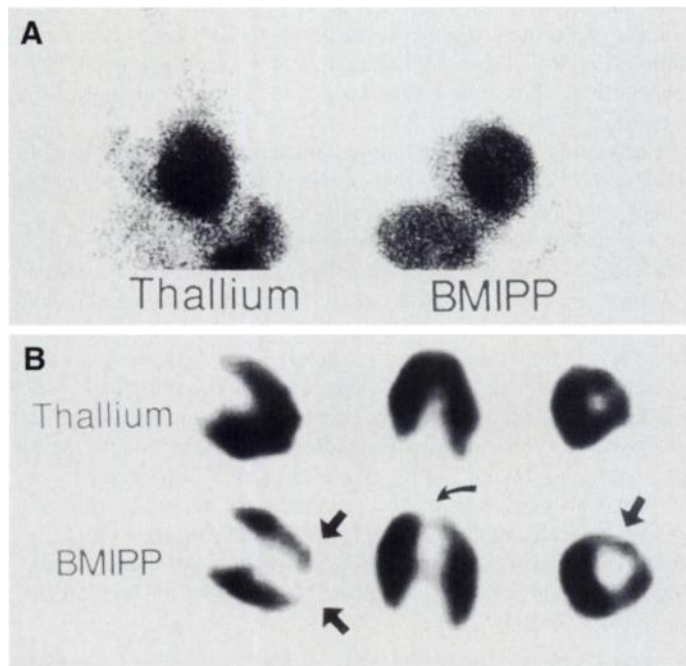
Planar (A) and tomographic (B) scintigrams of ^{201}Tl and BMIPP. Definitely reduced BMIPP uptake is seen at the left ventricular apex (large white arrow), which is more clearly visible in the vertical long-axis, horizontal long-axis and short-axis tomograms (small black arrows in lower panel). There is no perfusion abnormality, but the left ventricular walls are markedly hypertrophied on the ^{201}Tl scans.
